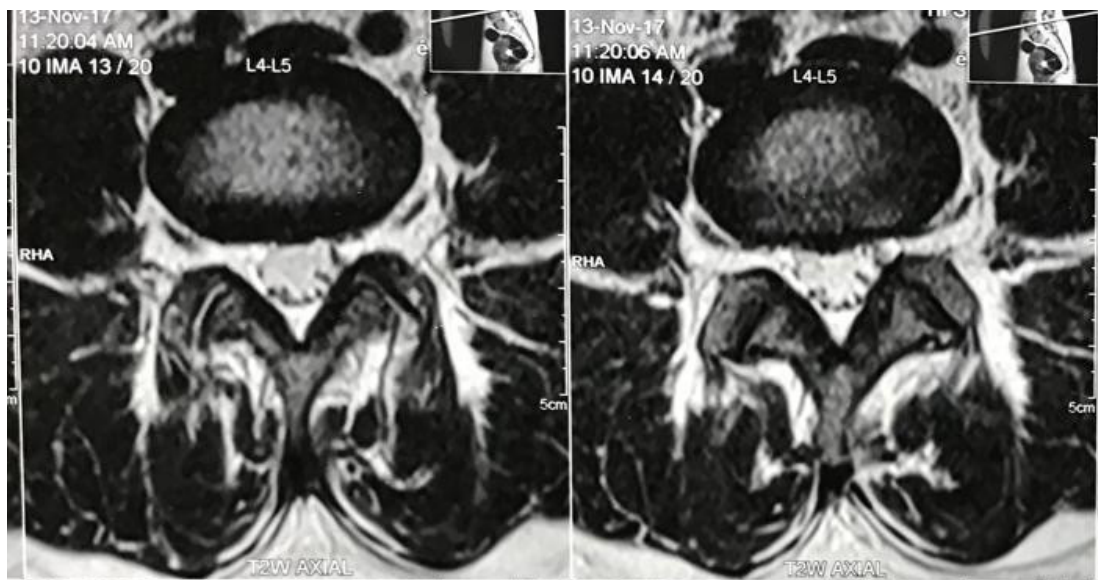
MRI Axial view of L4-L5 shows central bulge (MSU grade 1-A)
